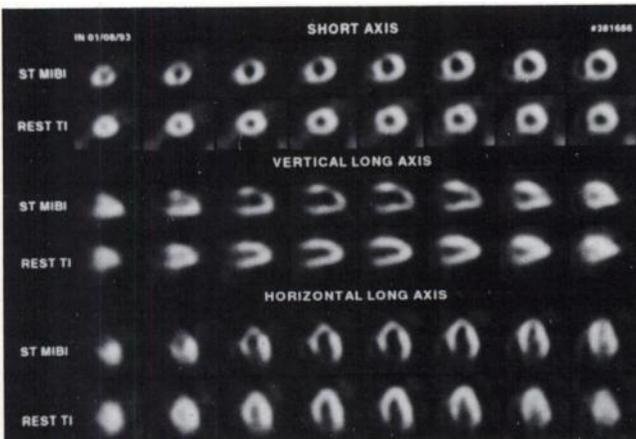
A normal case example of a separate acquisition rest  $^{201}\text{Tl}$  (bottom row) stress  $^{99\text{m}}\text{Tc}$ -sestamibi (top row) dual-isotope myocardial perfusion SPECT.
